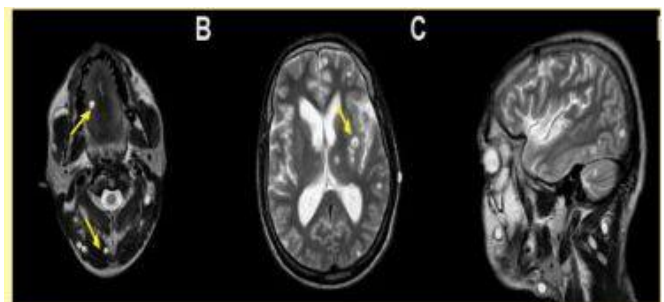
C): MRI brain showing cysticerci in parenchyma, ventricles, tongue and paraspinal muscles.
